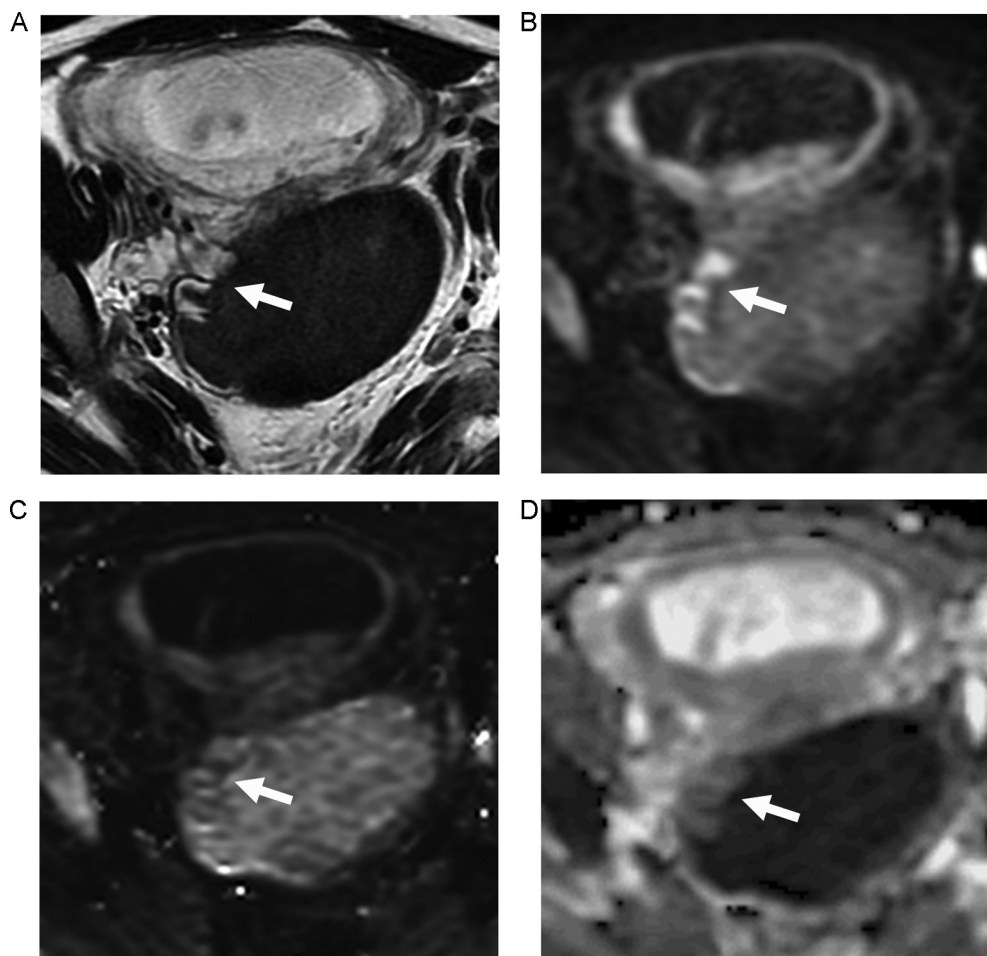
A 29-year-old pregnant woman with left ovarian decidualized endometrioma. A, Axial fast spin-echo T2-weighted image shows a unilocular cystic mass with “shading” and with very hyperintense small mural nodules (arrow). B, The mural nodules (arrow) show high signal intensities on DWI_{800} , and C, low signal intensities on $cDWI_{1500}$. D, The mural nodules (arrow) show high signal intensities on ADC map.
